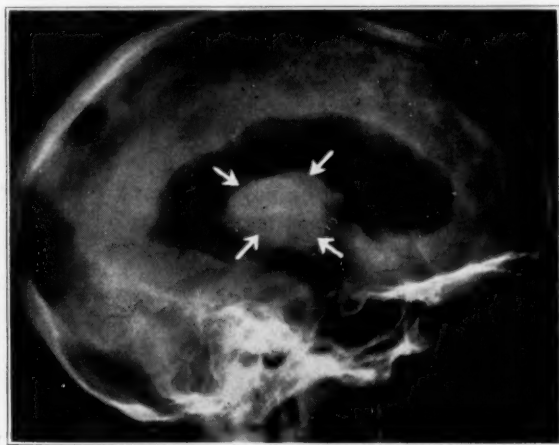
Lateral roentgenogram (ventriculogram) showing a large defect in the posterior portion of the third ventricle caused by a pinealoma; the normal sella turcica is unusual.
